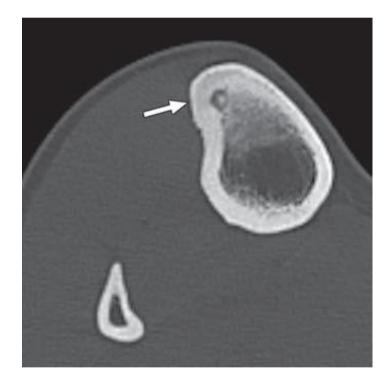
Axial plain CT shows central calcification within nidus (arrow) in tibial cortex, with sclerosis in anterior tibial medullary cavity (3).
